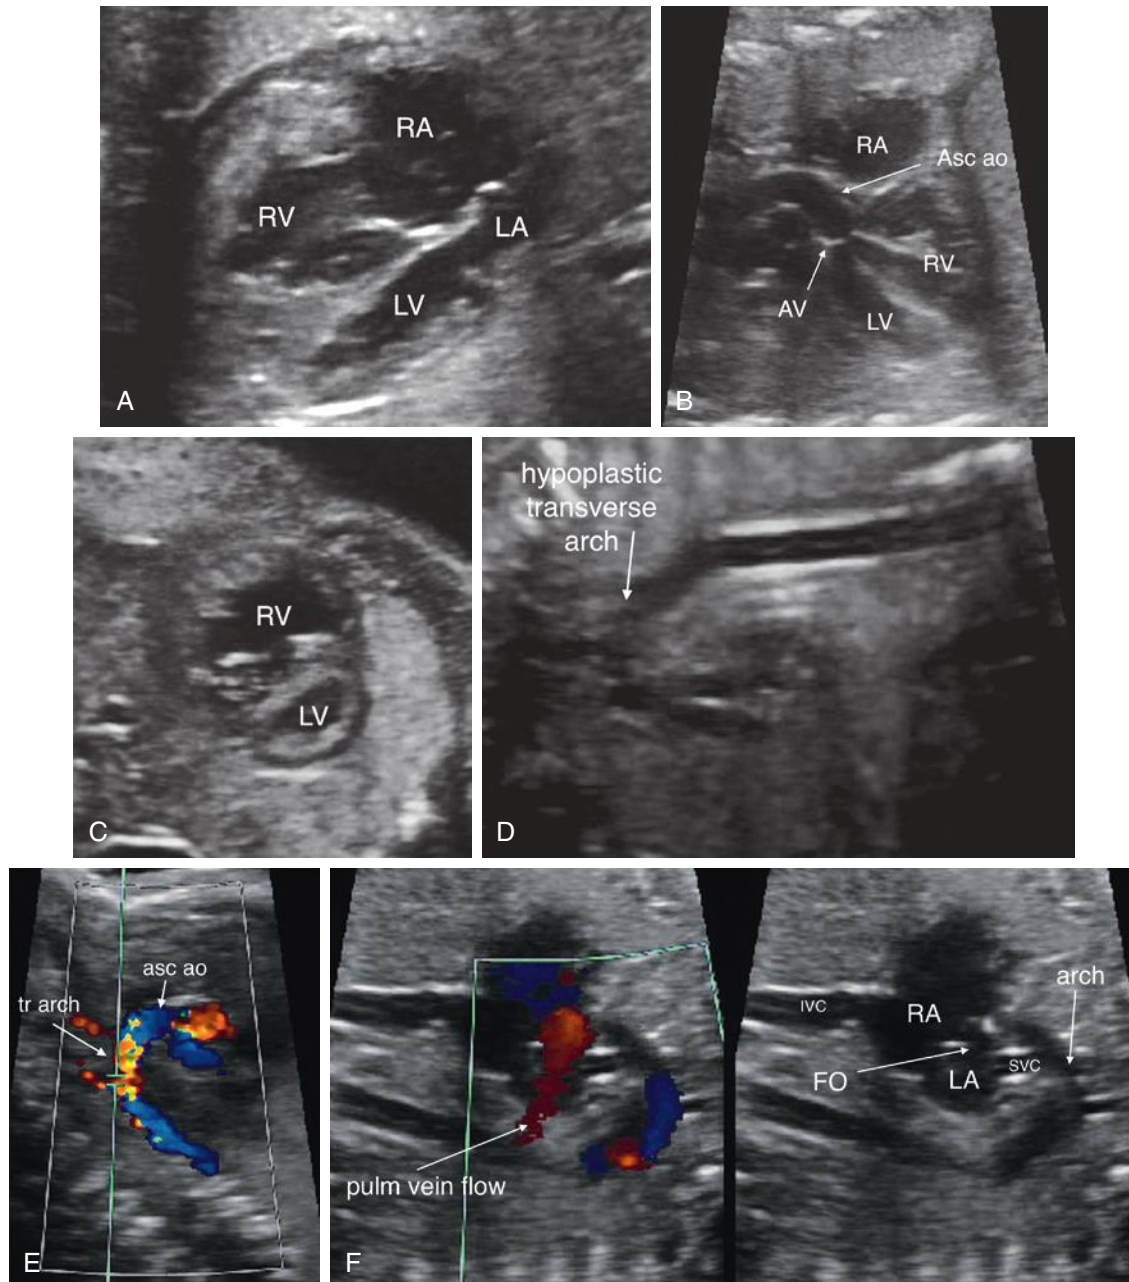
Left-sided heart hypoplasia/hypoplastic left heart complex/Shone complex. This form of left ventricular hypoplasia is almost universally associated with arch hypoplasia/coarctation of the aorta, mitral annular hypoplasia, aortic annular hypoplasia, and an apex-forming, but narrow left ventricle (LV). A, Four-chamber view of a long, thin LV with a hypoplastic mitral valve annulus. B, Left ventricular outflow tract view shows a hypoplastic aortic valve annulus. C, Low short-axis view shows that the LV is much narrower than the right ventricle (RV). D and E, Hypoplastic aortic arch that has retrograde flow by color Doppler, secondary to inadequate prograde flow across the left side of the heart. F, Atrial level shunting is typically bidirectional or left to right. Asc ao, ascending aorta; AV, aortic valve; FO, foramen ovale; IVC, inferior vena cava; LA, left atrium; pulm vein, pulmonary vein; RA, right atrium; SVC, superior vena cava; tr arch, transverse arch.
